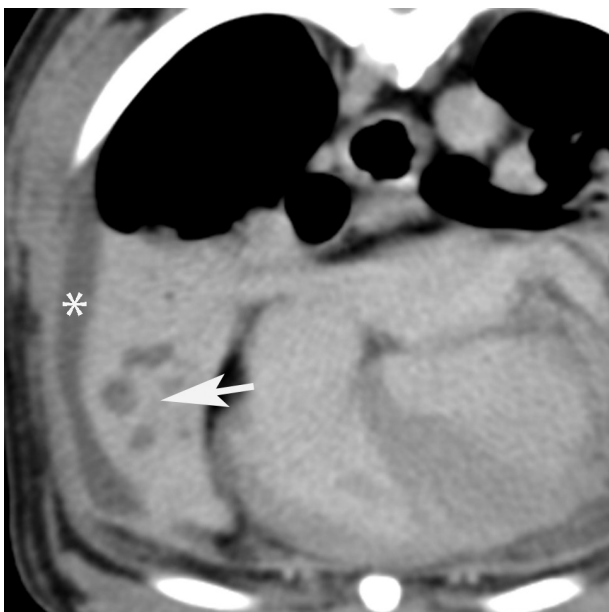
Enlargement of the CT image in Figure 1 obtained after administration of contrast medium. Fluid is evident in the pleural space (asterisk), and multiple small, noncontrast-enhancing, fluid-attenuating areas appear in the ventral aspect of the adjacent right middle lung lobe (arrow).
